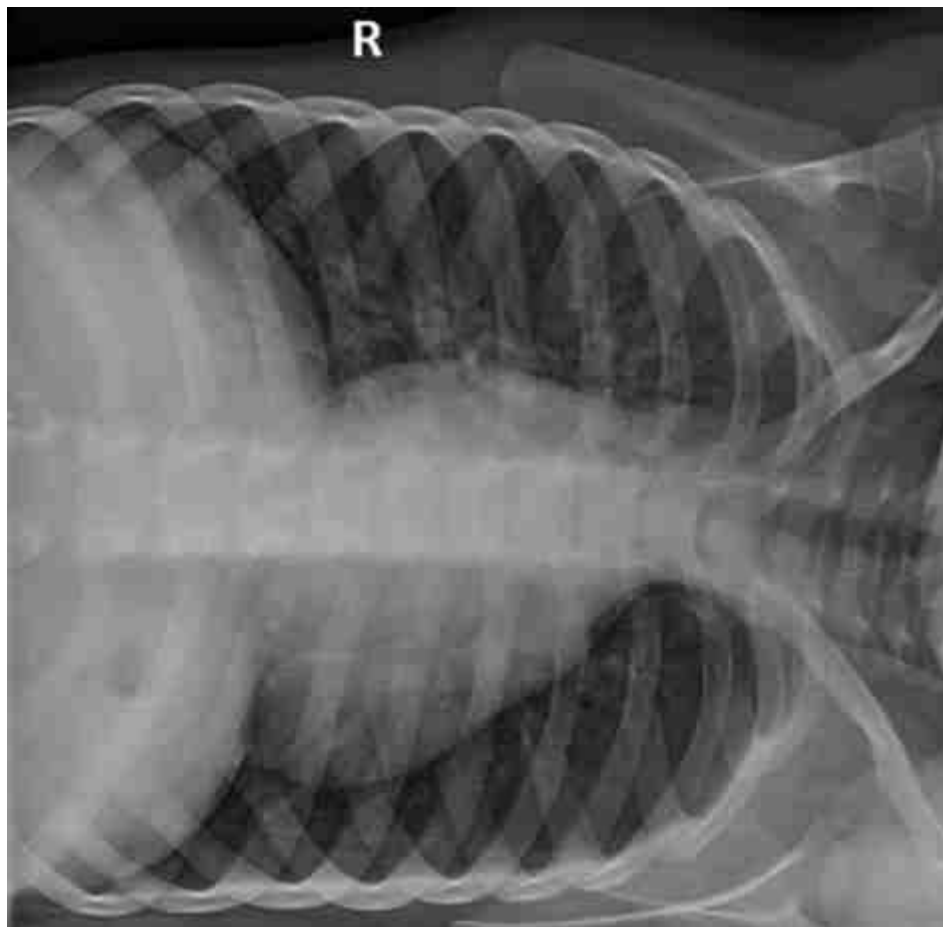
AP left lateral decubitus chest radiograph.
